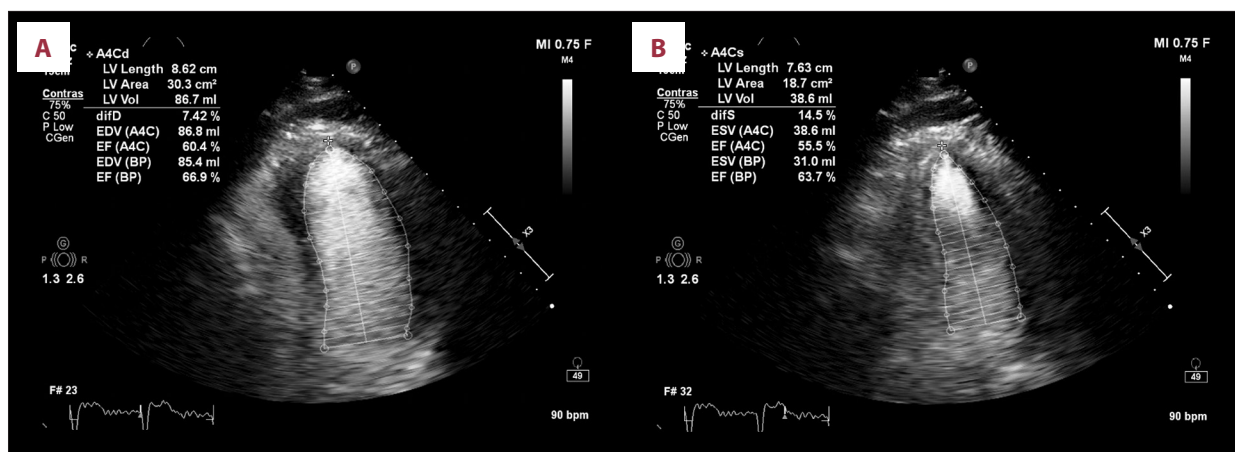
Apical 4-chamber view of transthoracic echocardiogram with Definity contrast (perflutren lipid microsphere) demonstrating preserved left ventricular ejection fraction (64%) in (A) end-diastole and (B) end-systole.
